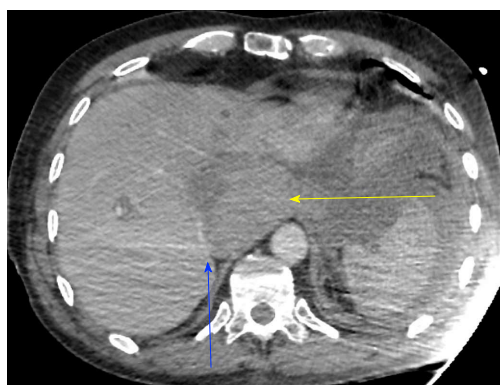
Injected abdominopelvic computed tomography showing extrinsic compression of the retrohepatic vena cava (blue arrow) by hematoma (yellow arrow).
